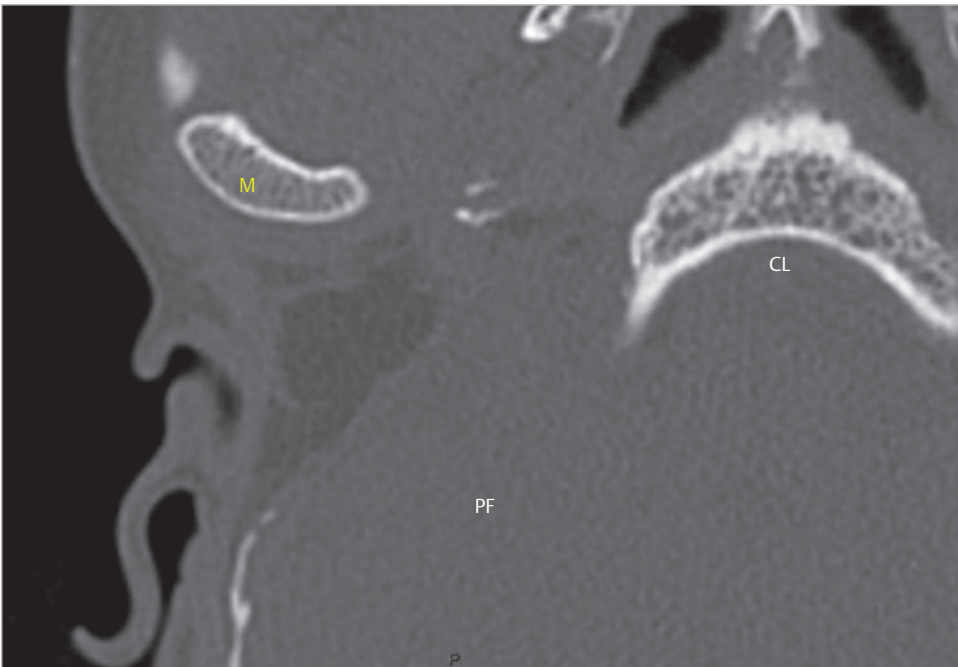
Postoperative CT demonstrates extensive removal of petrous bone. CL, clivus; M, mandible; PF, posterior fossa.
